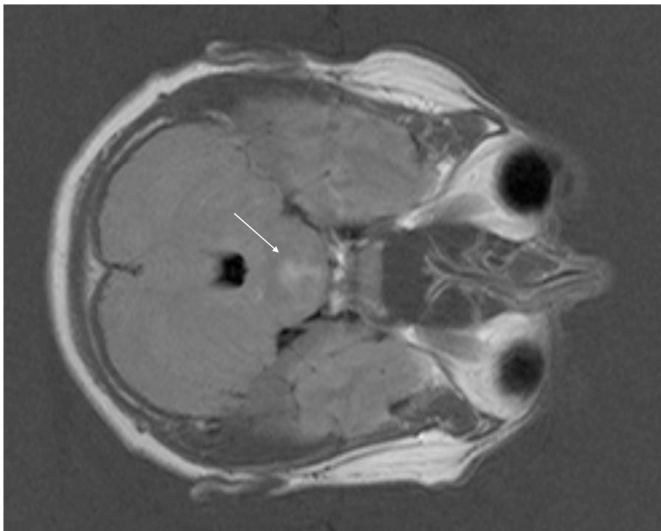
FLAIR at presentation with a diffuse lesion located centrally in the pons
